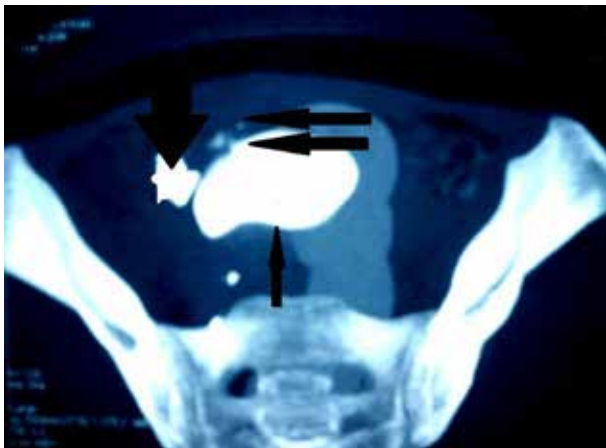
CT(abdomen, pelvis): arrow upward : urinary bladder, Thick arrow : right ovary, double arrow : fistula- tract.
